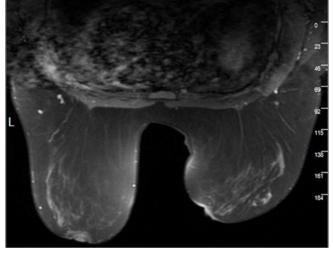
Postcontrast MRI images of ovoid shaped-hamartoma in the lower upper quadrant of the right breast as a lesion having both a fatty density fat-suppressed and contrast-enhanced glandular component inside
